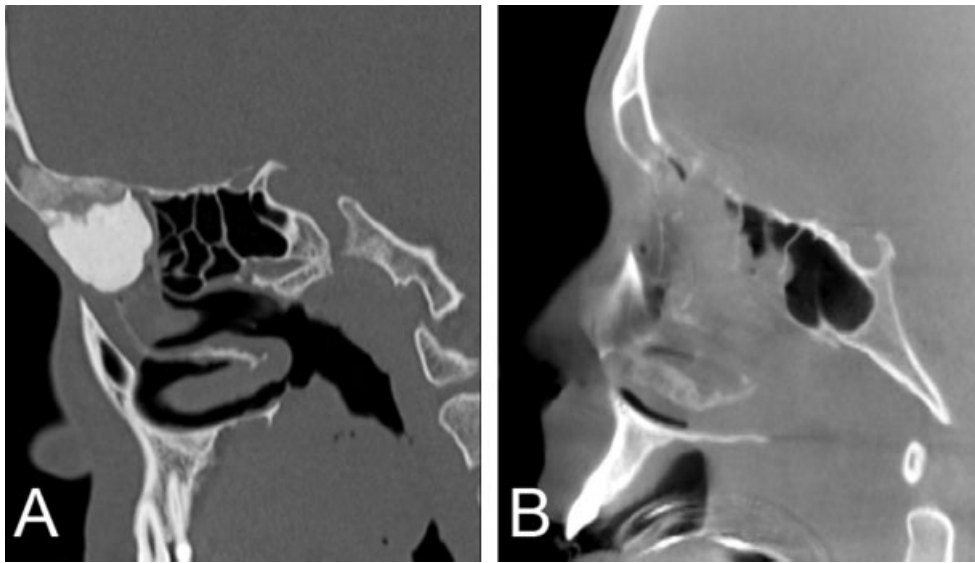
Giant osteoma (Case 11). (A) Conventional stealth CT and (B) intraoperative O-Arm CT demonstrating complete removal of osteoma with preservation of the skull base. This precise resection was facilitated by the high accuracy of the integrated intraoperative registration with image guidance system.
